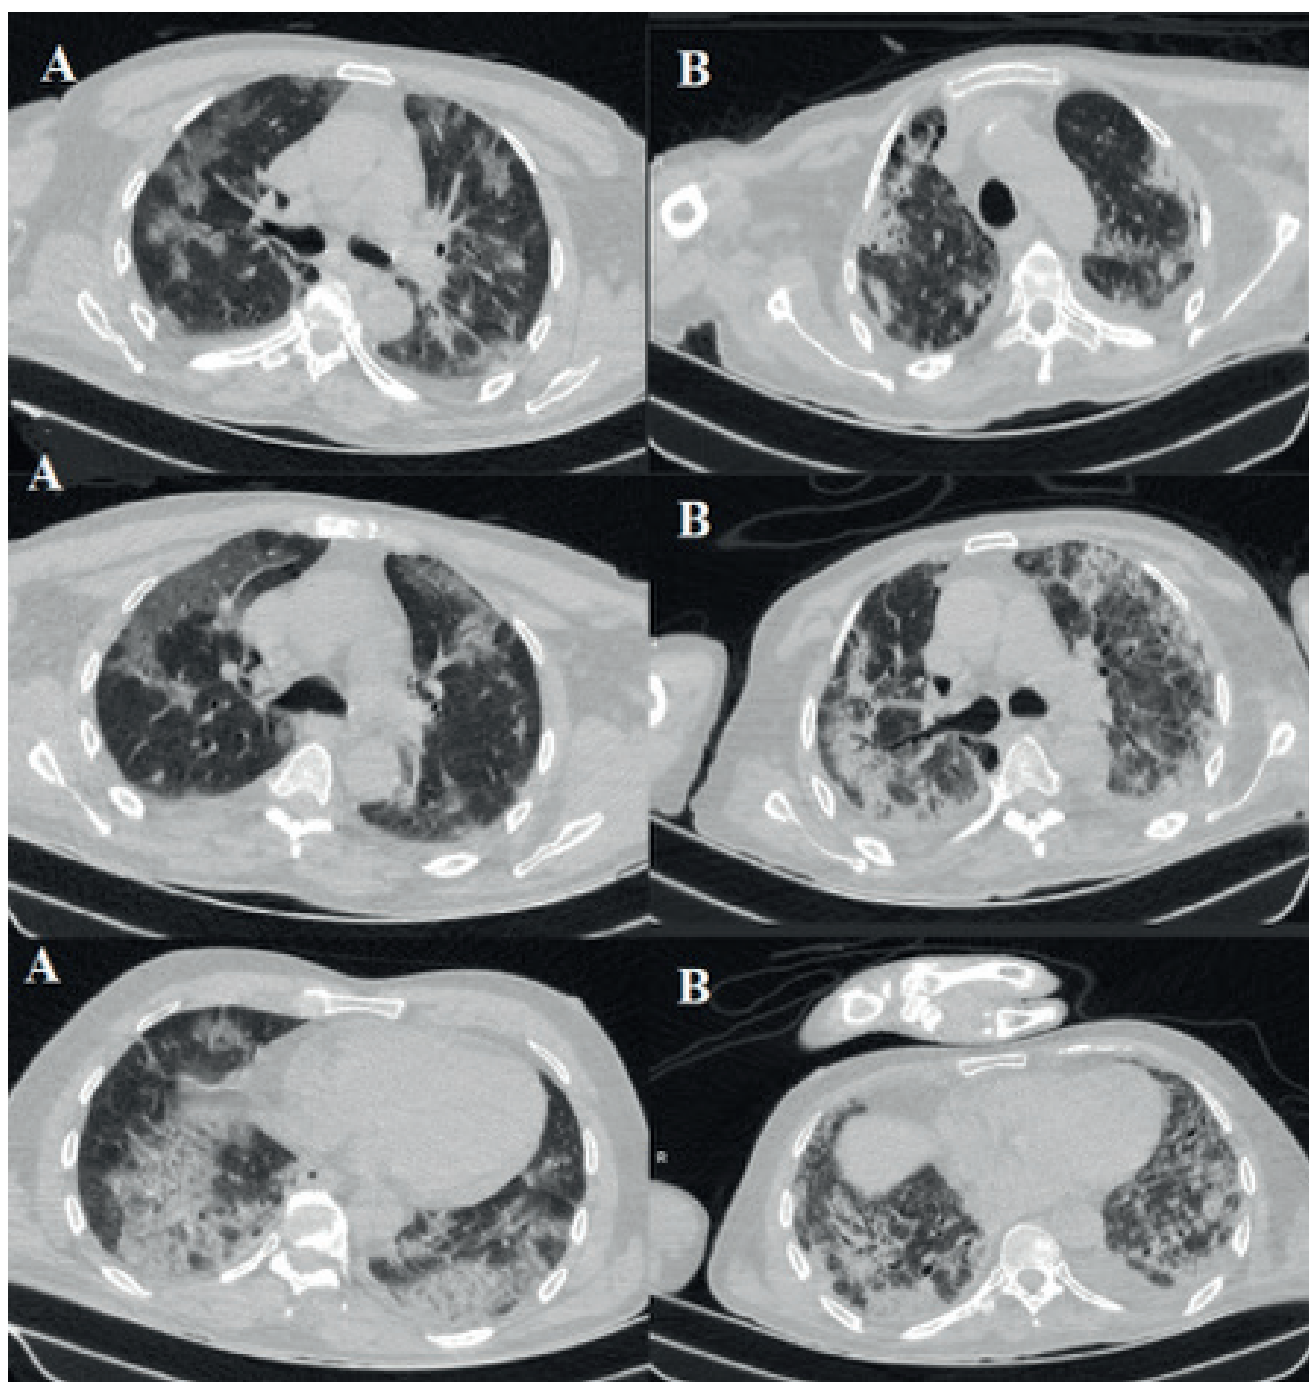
A: Thorax CT taken on the first day of hospitalization, diffuse ground-glass opacities, B: Thorax CT taken on the 52nd day of hospitalization, fibrotic tissues.
